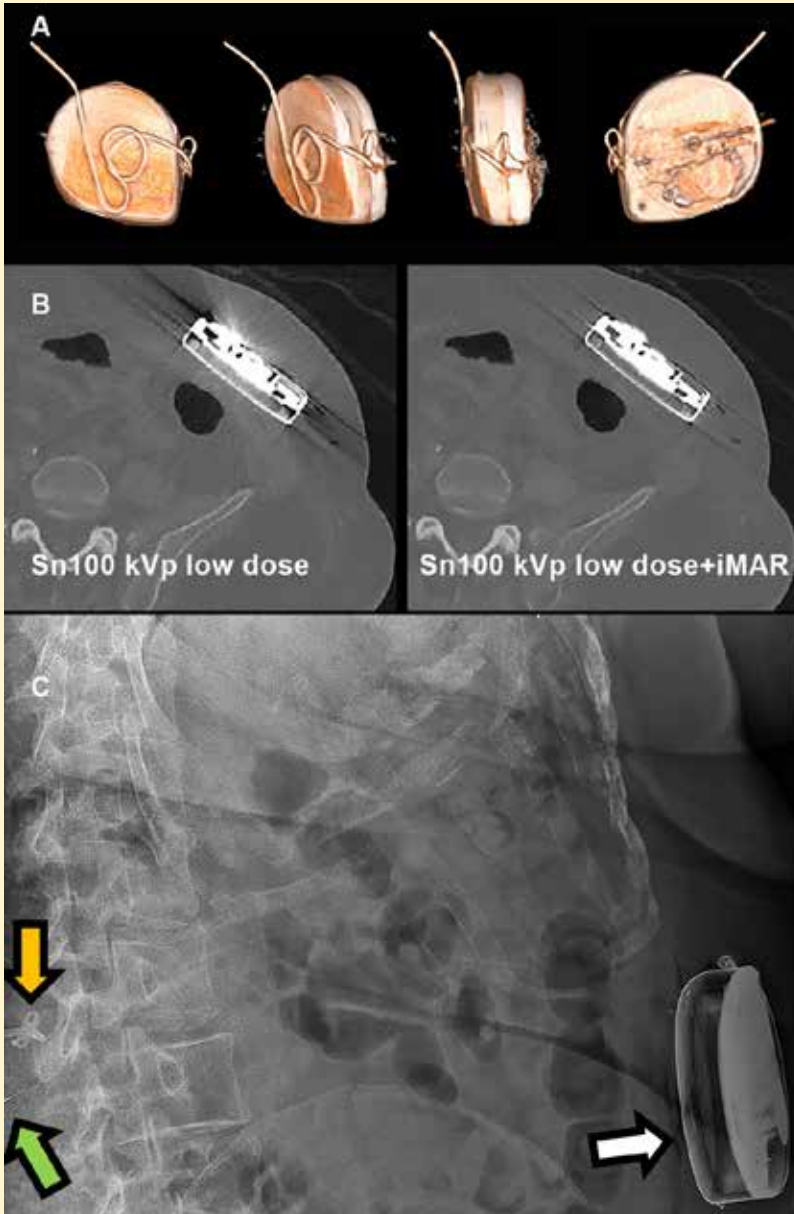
Surplus catheter behind the pump 3D VRT reconstruction (A) with iterative metal artifact reduction reconstruction algorithm (B) showing a normal course of surplus catheter length behind the pump, which is invisible on plain radiography (C, white arrow) and CT (B). The Ascenda catheter cannot be followed along its track on plain radiography (C); The only structures visible are the catheter–catheter connector (green arrow) and the fixation anchor (orange arrow).
